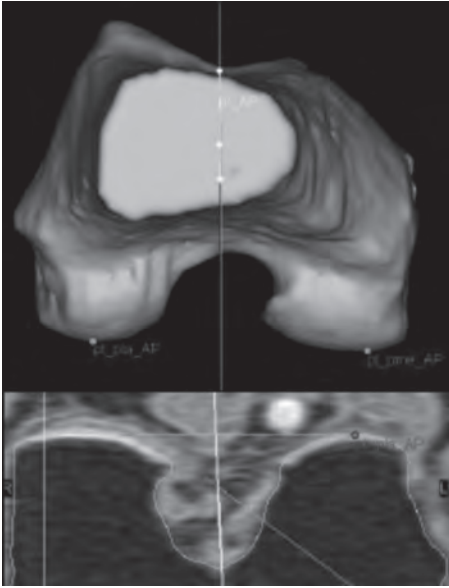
Example of manual segmentation of MRI: femoral posterior points.
